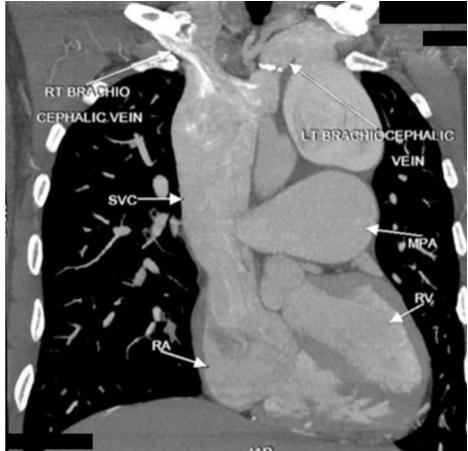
Coronal cardiac CT
